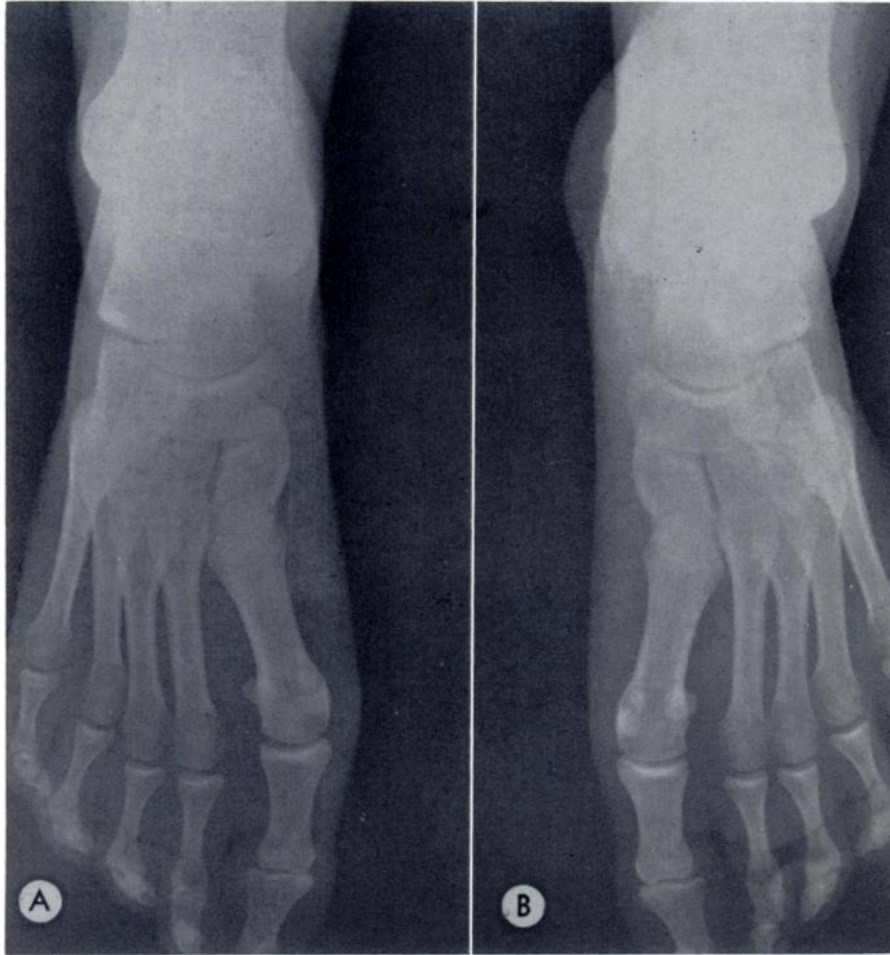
Case 1. (A and B) Anteroposterior roentgenograms of the feet. Faint striations are seen in the first metatarsals, being more prominent on the left (B).
